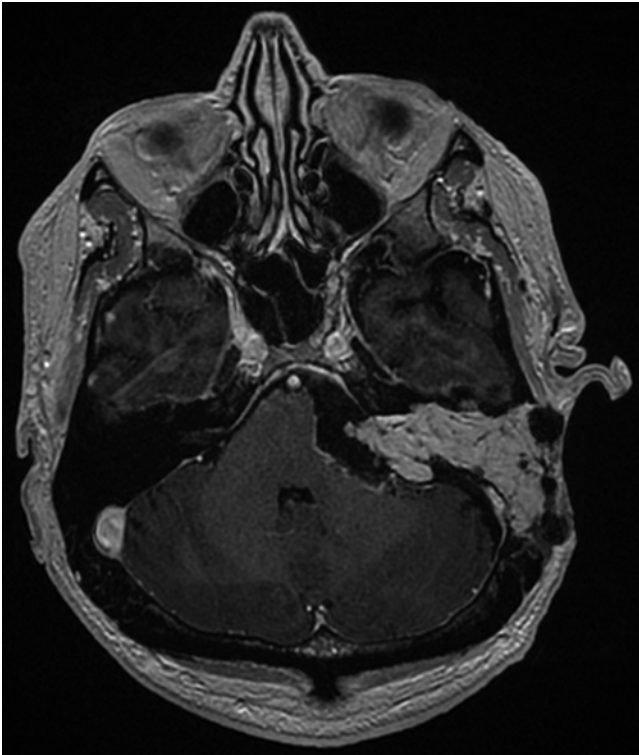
Postoperative axial contrast-enhanced T1-weighted MR image demonstrating the extent of resection of the tumor and fat strips placed in the surgical cavity to the level of the dural defect.
